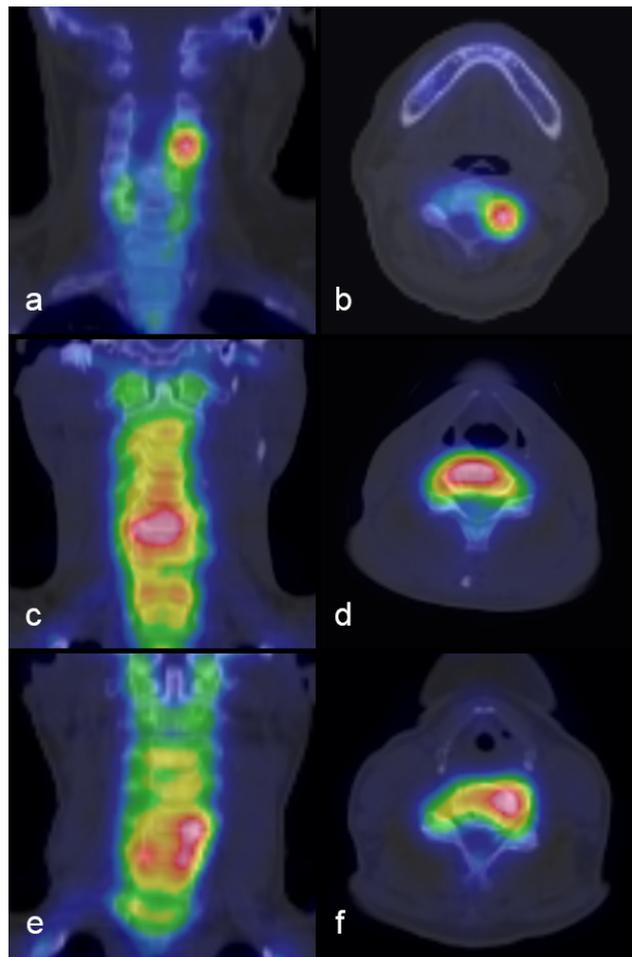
Three different locations of increased radiotracer uptake in coronal and axial view of SPECT/CT. (a,b) The facet joint. (c,d) The endplates. (e,f) The uncovertebral joint.
